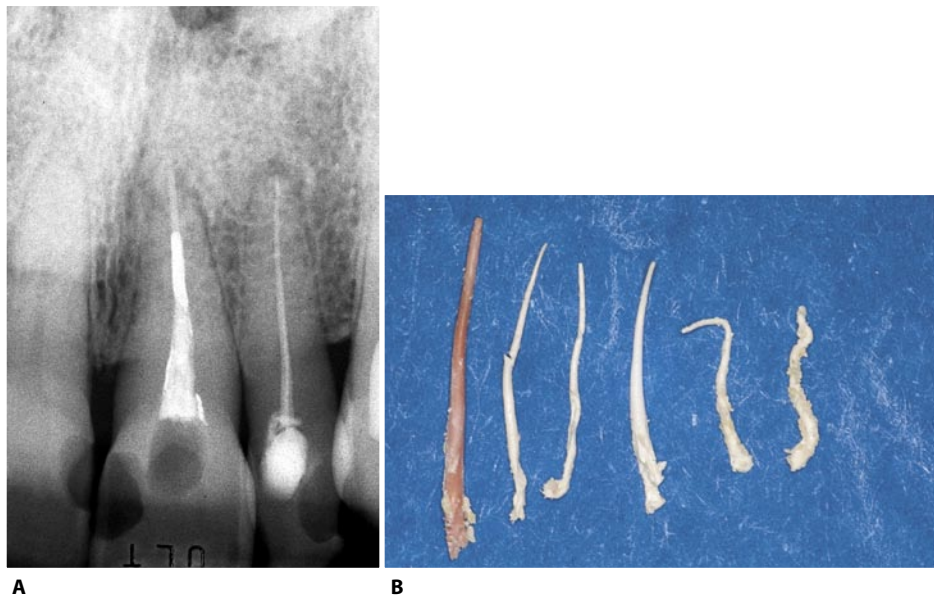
A. Preoperative radiograph of an upper central incisor requiring retreatment. B. These are the gutta-percha cones that were used to obturate the root canal using the cold lateral condensation technique. It was possible to remove every single cone that was used!
